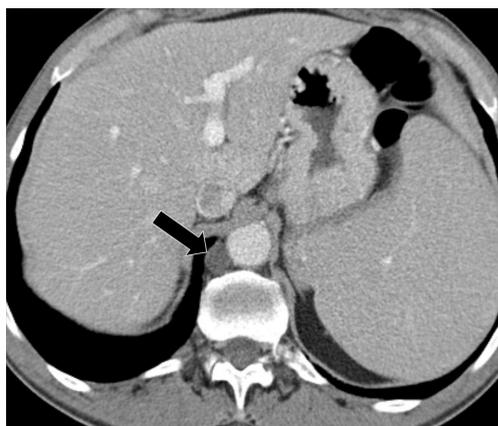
80-year-old male. CT image demonstrates a classic appearance of the cisterna chyli, a fluid-attenuation lesion located immediately to the right of the aorta at its diaphragmatic hiatus (black arrow). CT, computed tomography.
